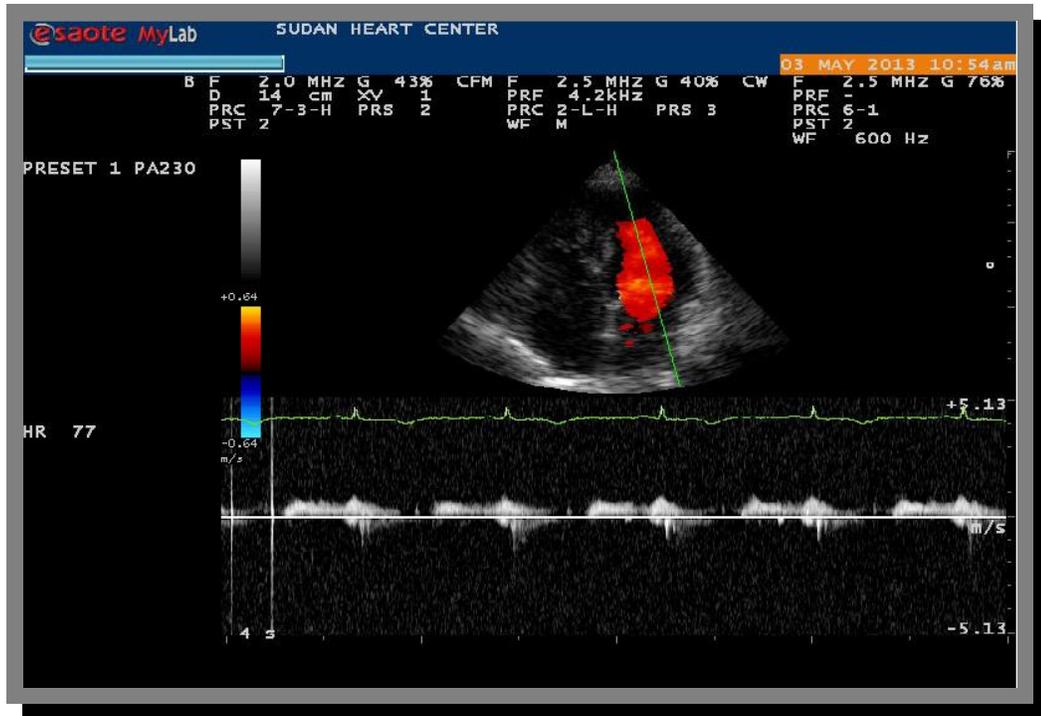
Continuous wave Doppler assesses the blood flow in of mitral valve.
